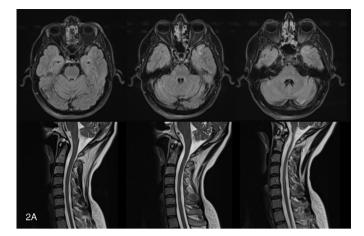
MRI findings of the patient MRI: Magnetic resonance imaging
